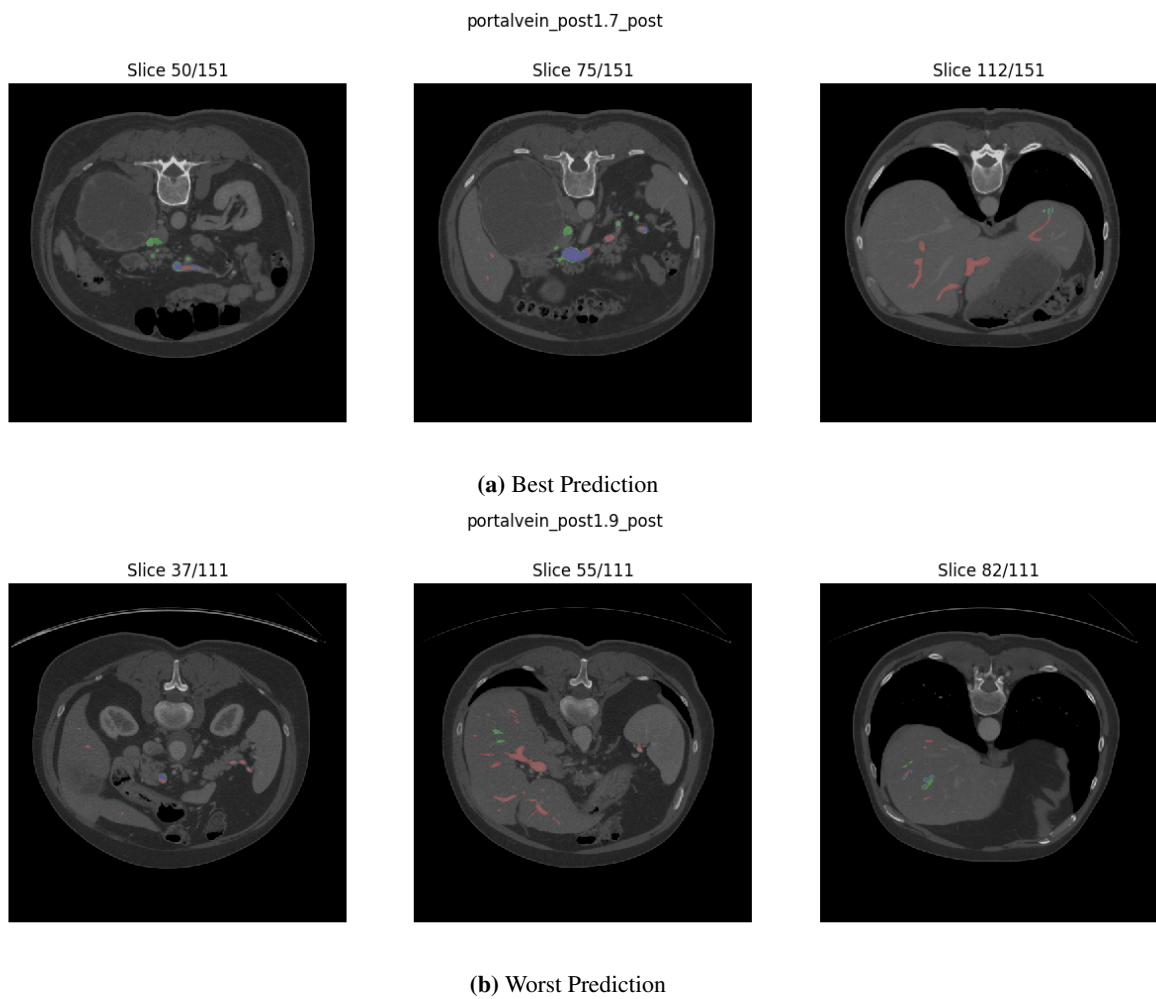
A selection of some of the CT slices of the BVNet model's best and worst prediction of the portal vein splits, where the corresponding Prediction is overlaid. The prediction is color-coded with blue=TP, green=FP, and red with low opacity=FN
